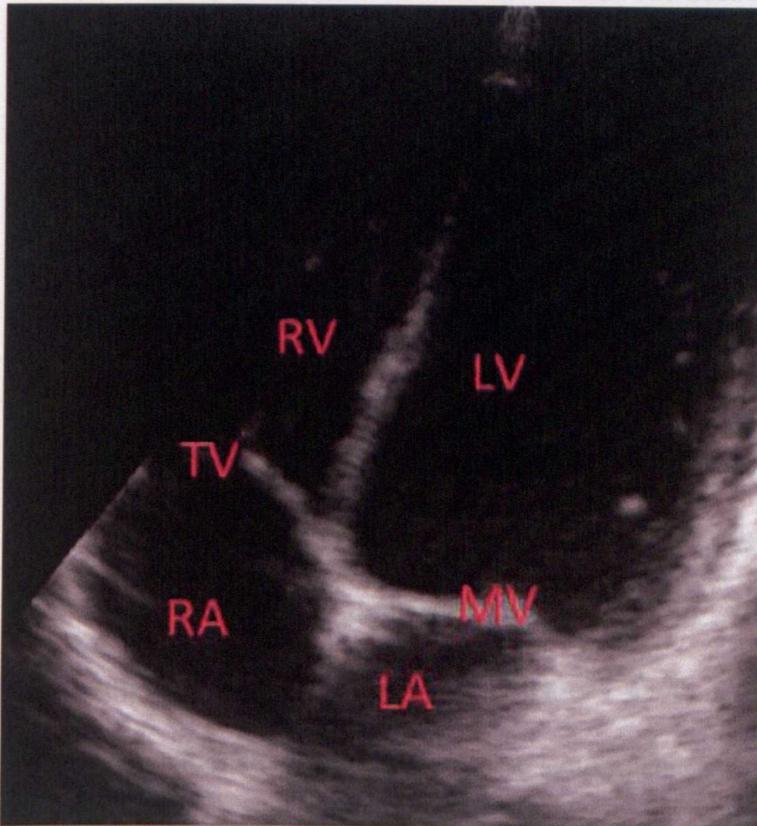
Apical four chamber view of heart. Author's own Scan: Image taken from one of participants in Study 2.
